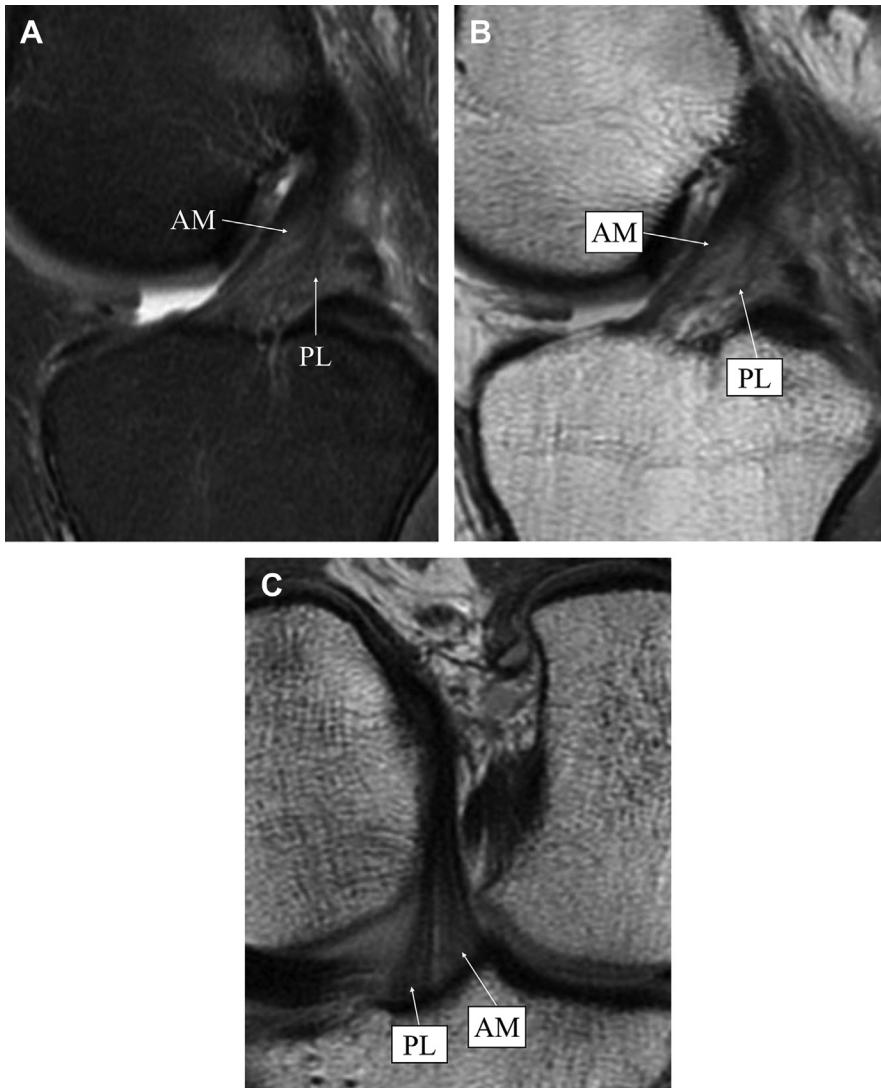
ACL MRI showing both bundles. (A) T2 Sagittal. (B) T1 Sagittal. (C) T1 double oblique.
